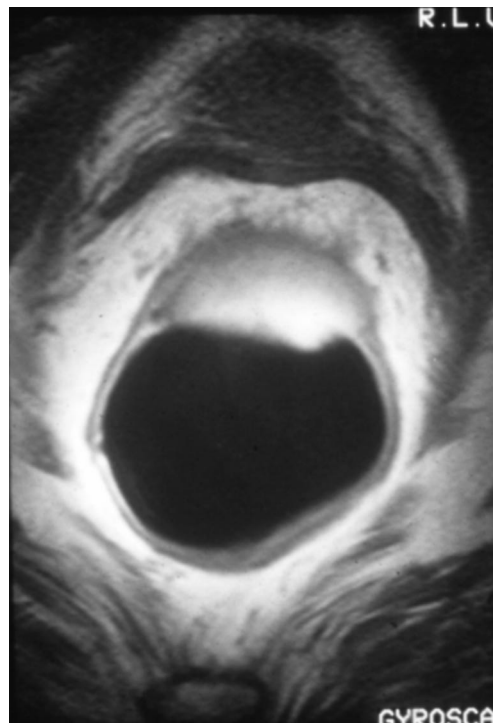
Intra-anal magnetic resonance imaging scan showing T3 tumour, which is not suitable for local treatment.
